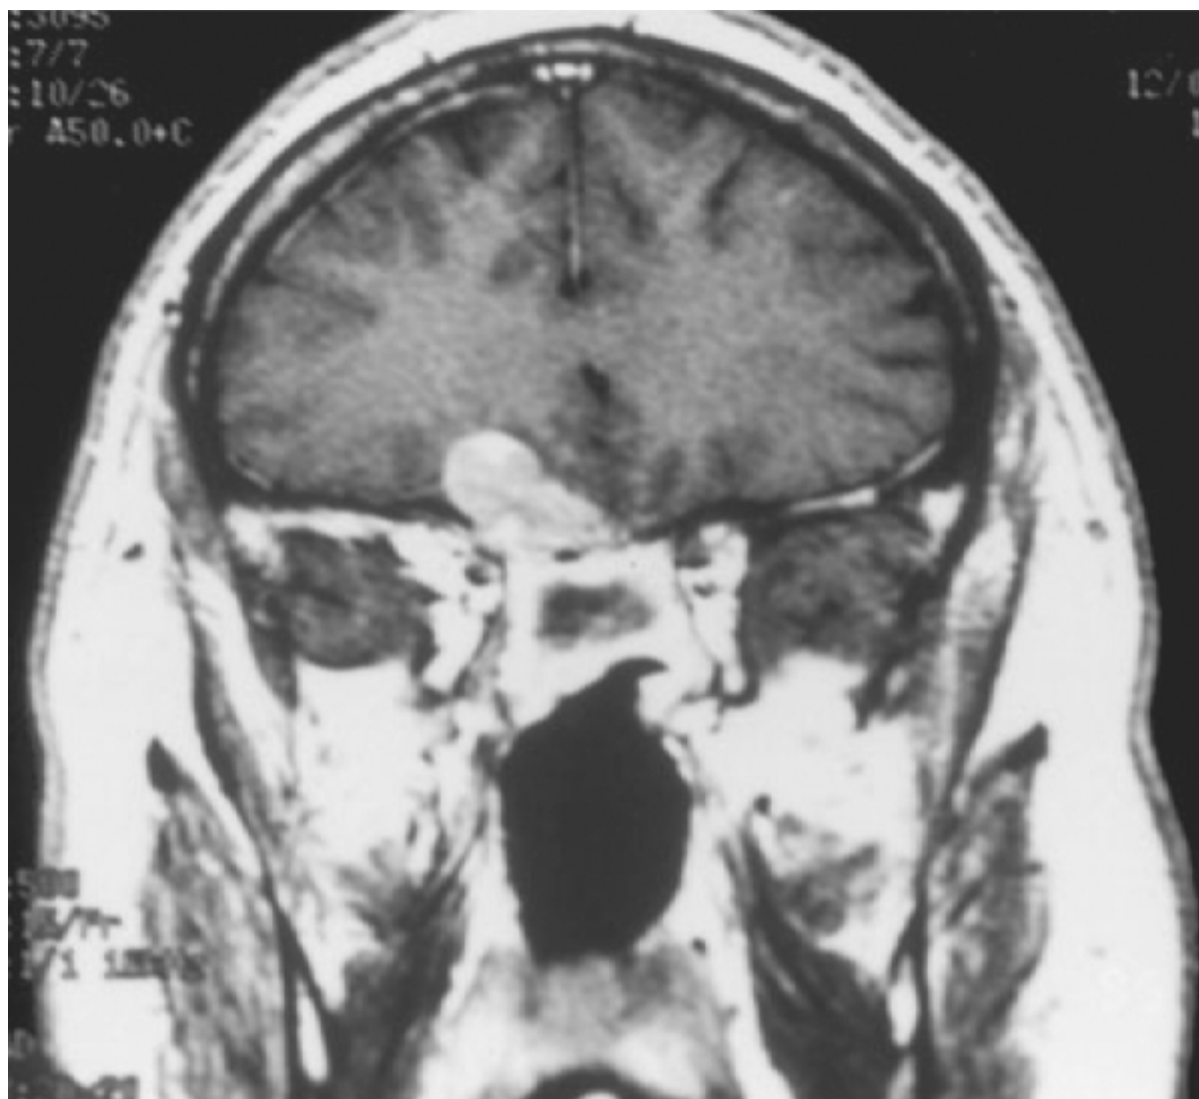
In this patient, squamous cell carcinoma developed in an inverting papilloma. Magnetic resonance imaging demonstrates minimal tumor invasion of the right frontal lobe.
